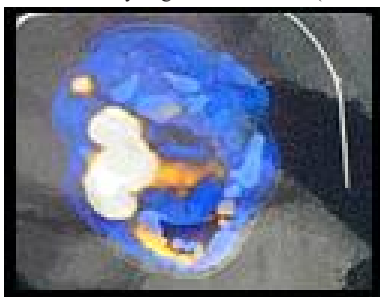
FDG PET-CT demonstrating the metabolically active primary tumour with ipsilateral cervical lymph node metastasis.
